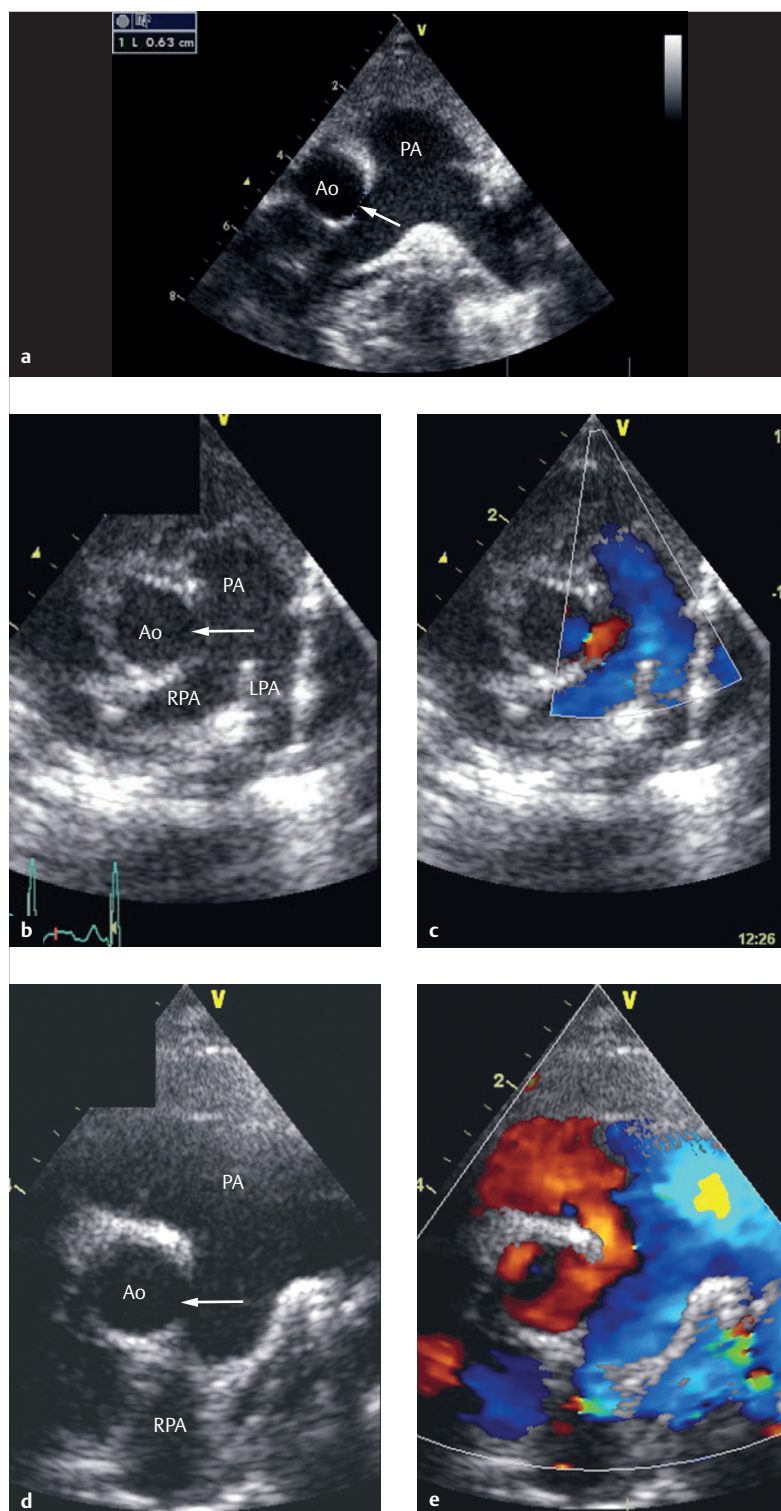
Distal APSD. Each arrow indicates the position of an APSD. Doppler echocardiography exams, various patients.
